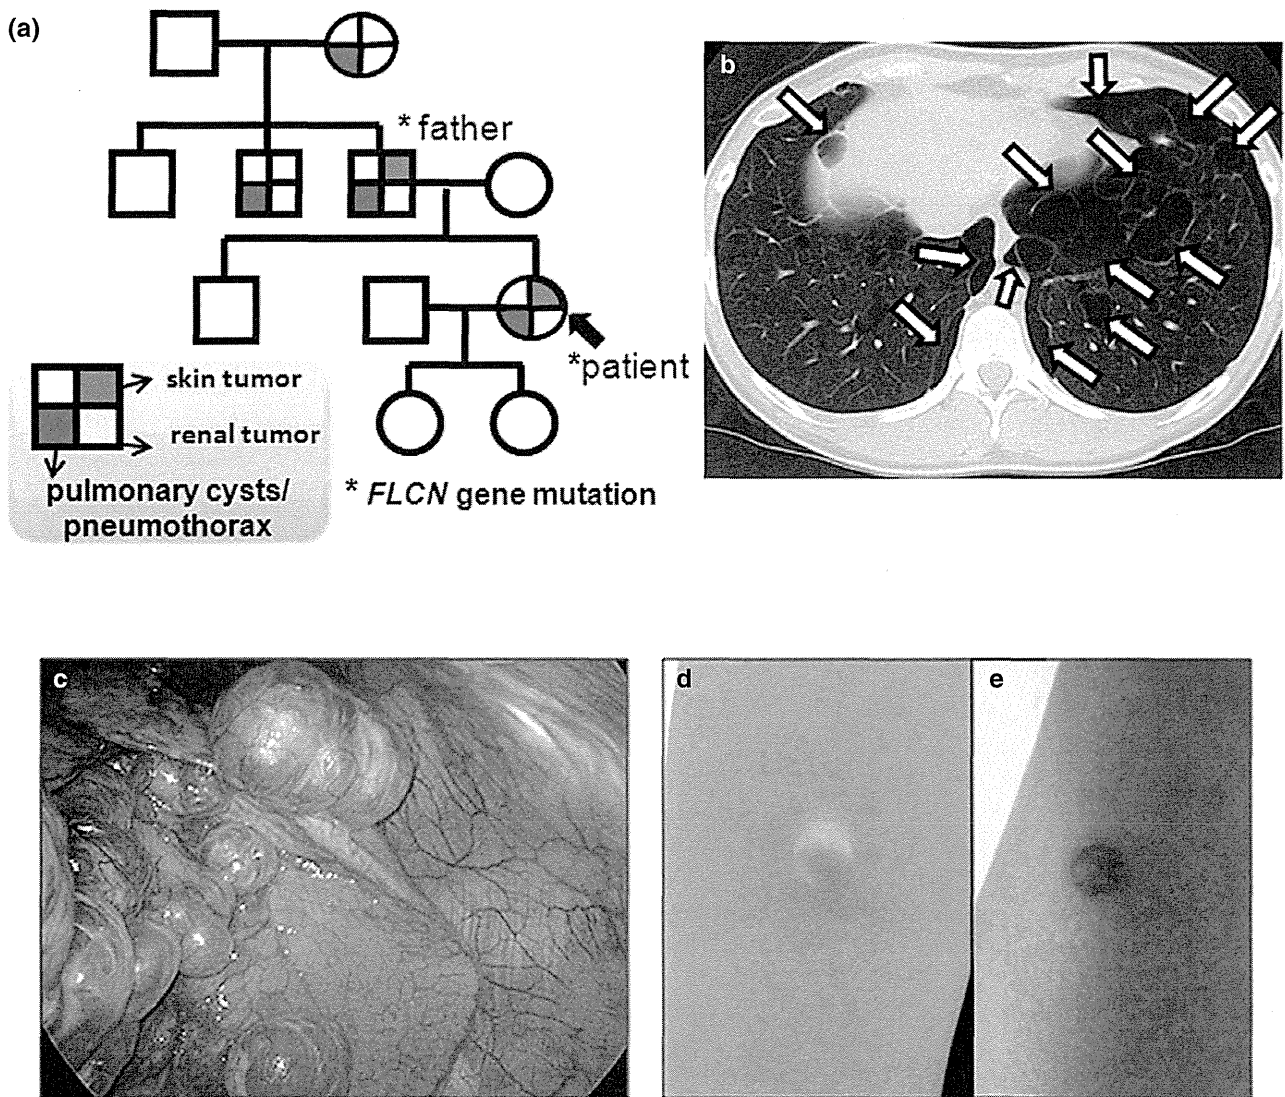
Inheritance of phenotypes, and radiologic and macroscopic findings. (a) Pneumothorax is the main manifestation of this family. The patient has repeated pneumothorax and multiple pulmonary cysts. Her father and uncle also have a history of pneumothorax. (b) Thoracic computed tomography of the patient's chest, indicating the predisposing condition to further rupture of the remaining cysts (arrows). (c) The thoracoscopy reveals multiple subpleural cysts in the lower lobe. (d) A skin tumor in the right upper arm of the patient, and (e) in the left forearm of the father.
